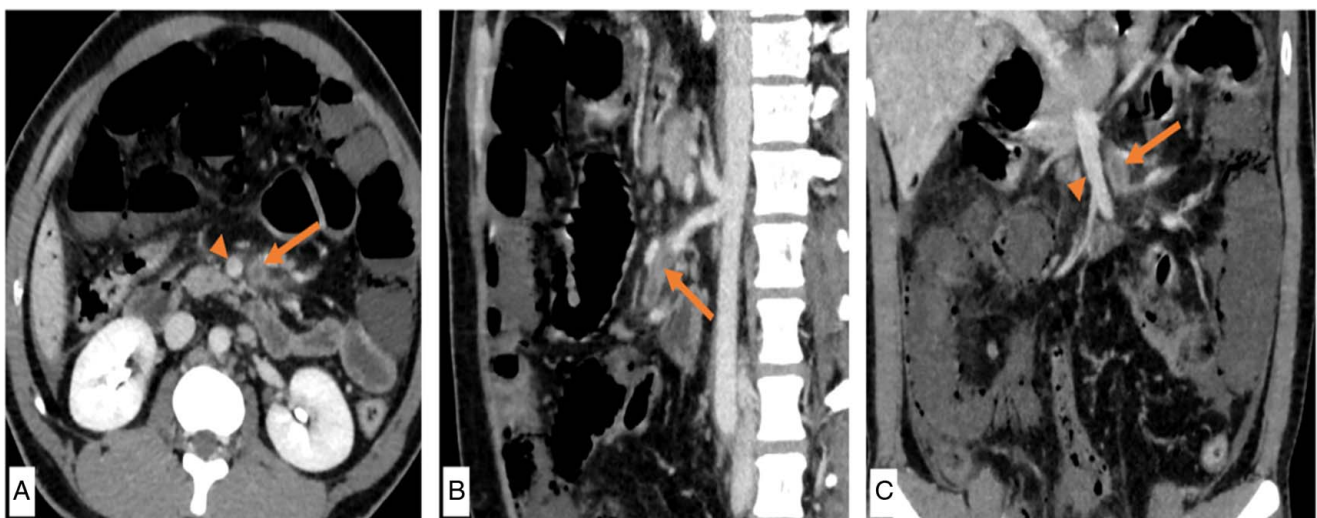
Contrast-enhanced computed tomography images of the abdomen in axial plane (A), oblique sagittal section (B), and coronal plane (C) show normally opacified abdominal aorta with its branches, celiac artery (superiorly), and superior mesenteric artery (SMA) (inferiorly); SMA shows the presence of nonenhancing filling defect (orange arrow) starting ~2.2 cm distal to its origin with mildly thickened enhancing wall in the involved segment in keeping with 'SMA thrombosis.' 'Orange arrowhead: superior mesenteric vein. The presence of pneumatosis intestinalis is also demonstrated as described in previous images. Minimal perihepatic ascites is noted (A, C).
